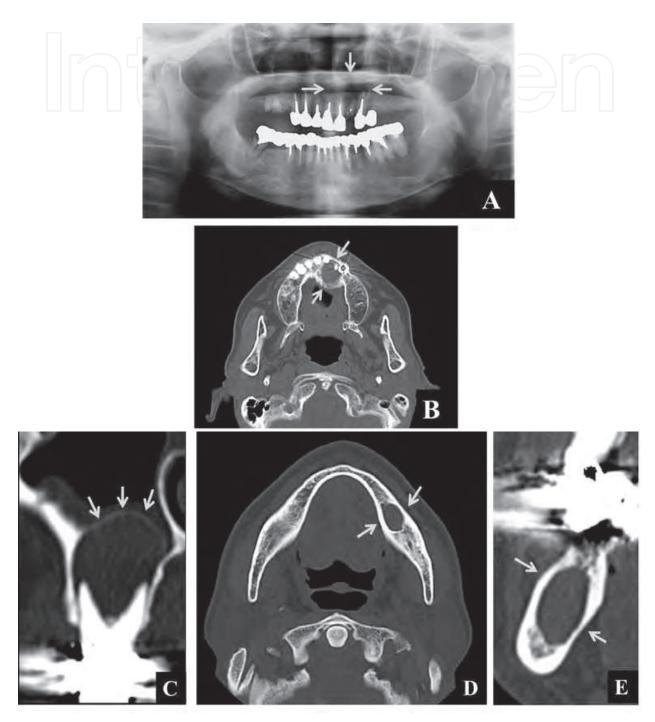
Panoramic radiograph image (A), axial CT image (B) of a radicular cyst in the maxilla (arrows). Oblique coronal CT image (C) of a radicular cyst extension into the maxillary sinus from the maxillary sinus floor (arrows). Axial (D) and oblique coronal (E) CT images of the residual cyst in the left mandible (arrows).
